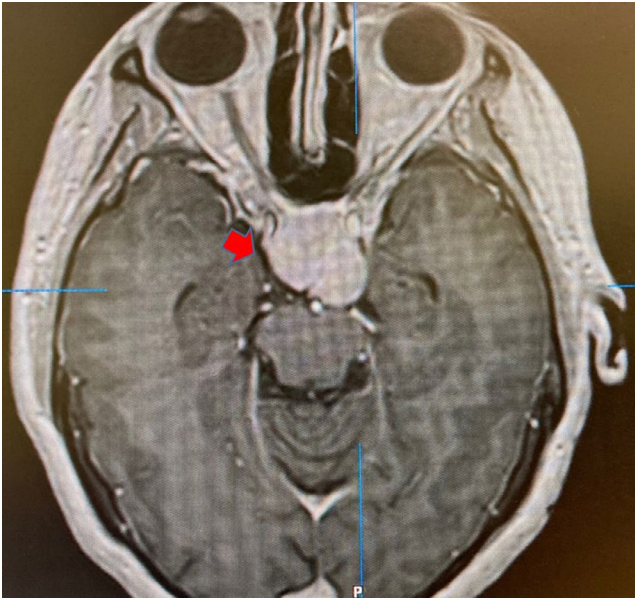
Preoperative contrast T1, axial MRI of the extra-axial meningioma at the sellar and suprasellar region (Arrow)
